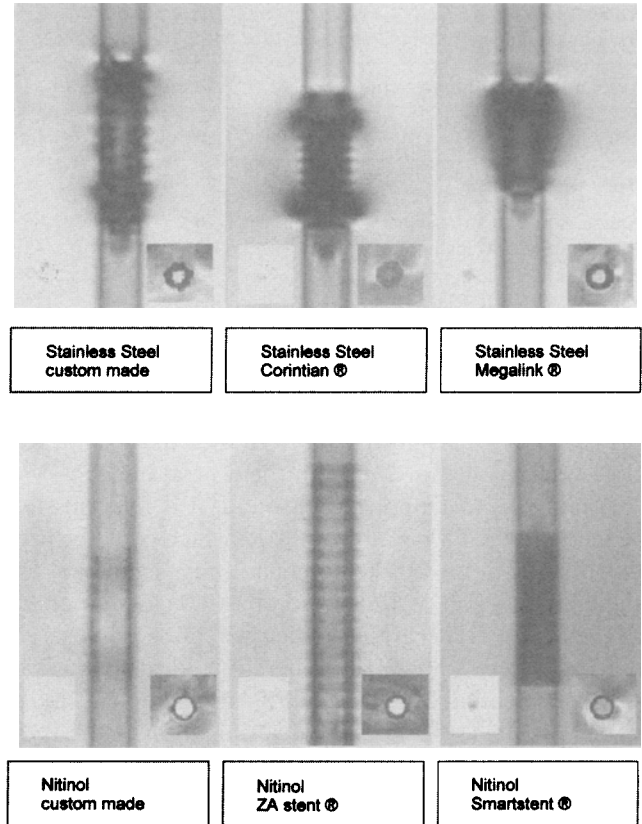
Coronal MR scout images and axial MR images of the used vascular stents showing the different artifacts of each stent. (See text for detailed discussion.)
